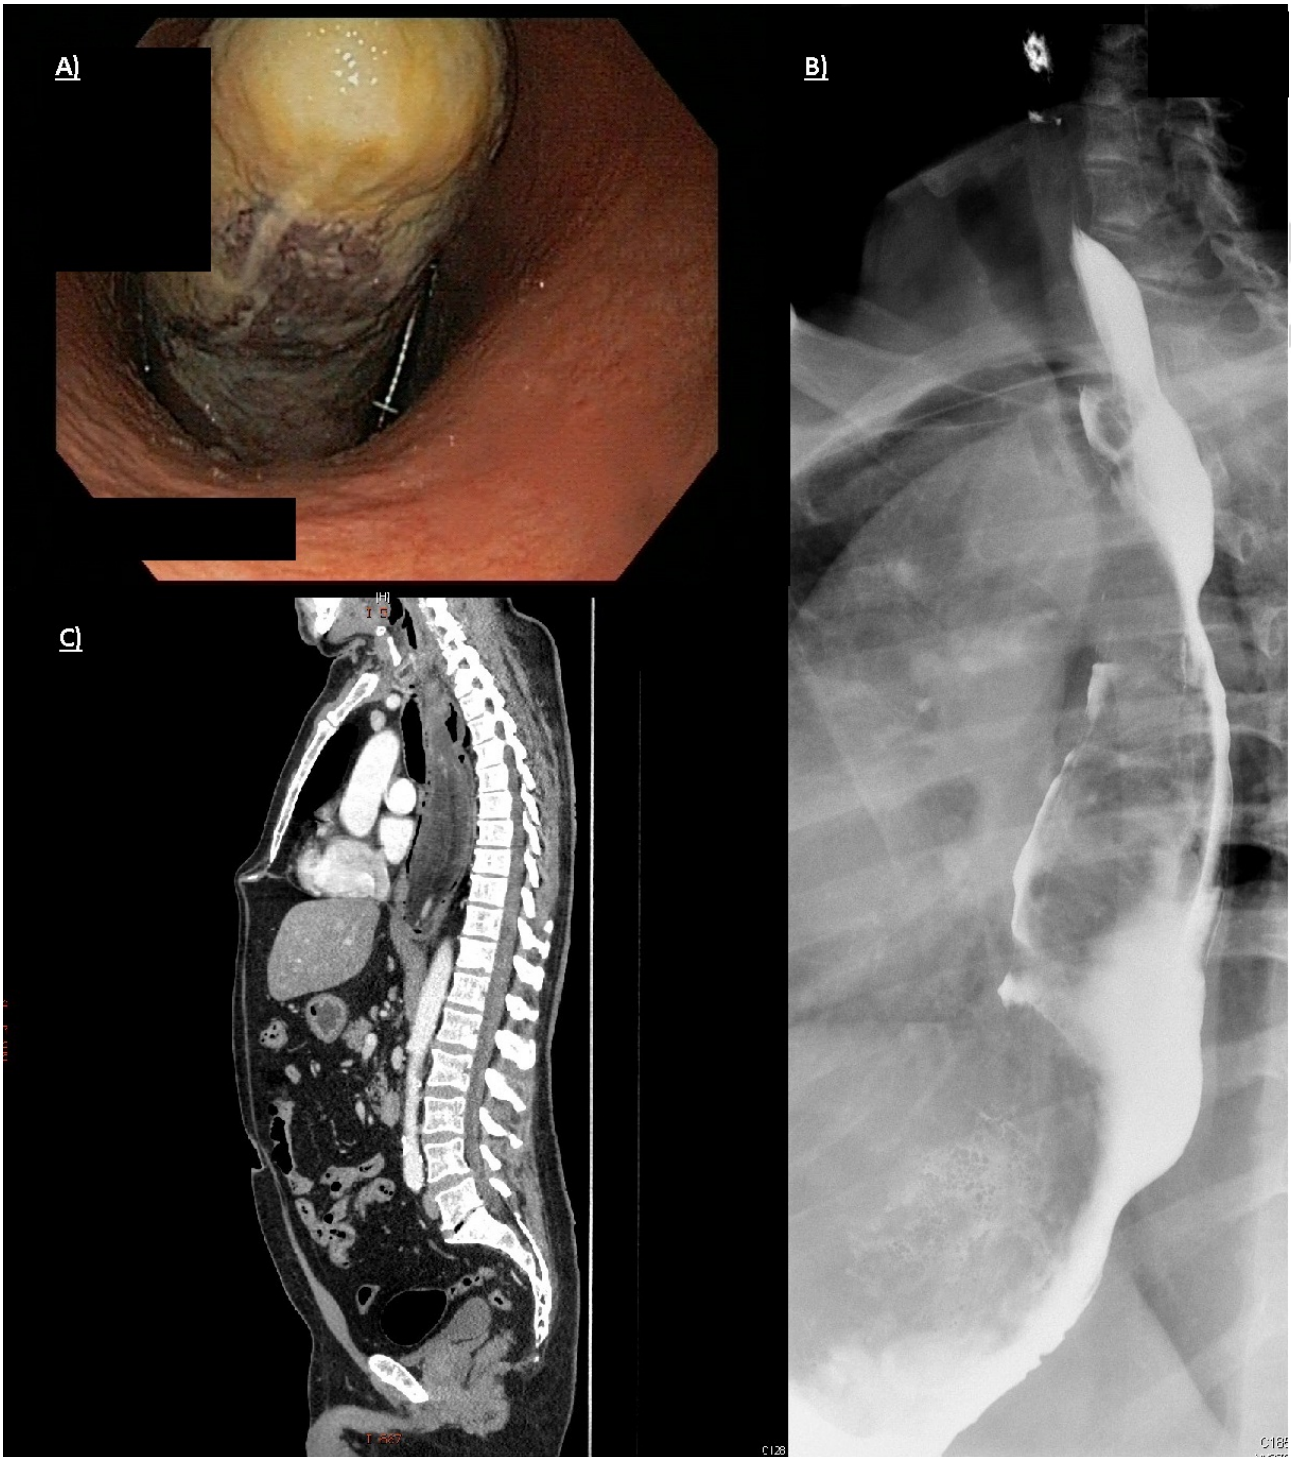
A. Gastroscopy: an ulcerated fibrovascular polyp seen in retroversion from the gastric chamber. B. Barium study: a large radiolucent endoluminal lesion of 25-30 cm in size extending from the upper third of the esophagus to the fundus, resulting in an esophageal dilation. C. CT scan: an endoluminal mass involving the entire esophagus and gastric fundus, with prominent intra-lesion blood vessels.
